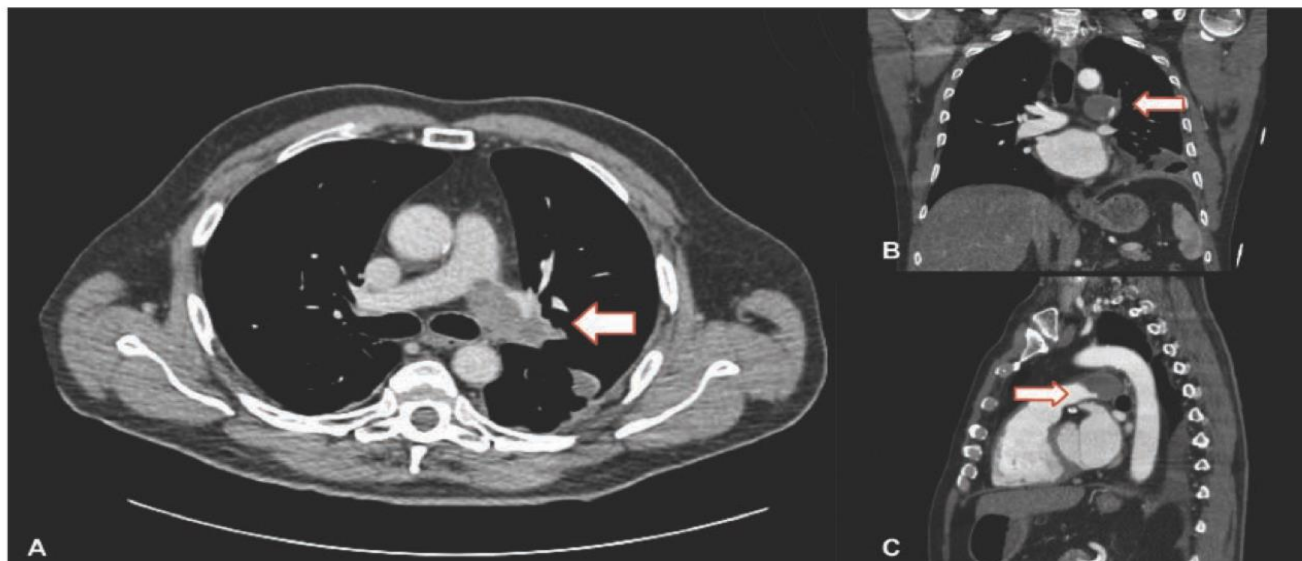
Computed tomography angiograms of the patient's thorax after four weeks of warfarin treatment. A large obstructive lesion (arrows) is visible in the left pulmonary artery, extending into the pulmonary trunk. The lumen of the left pulmonary artery is almost completely obliterated by the lesion.
